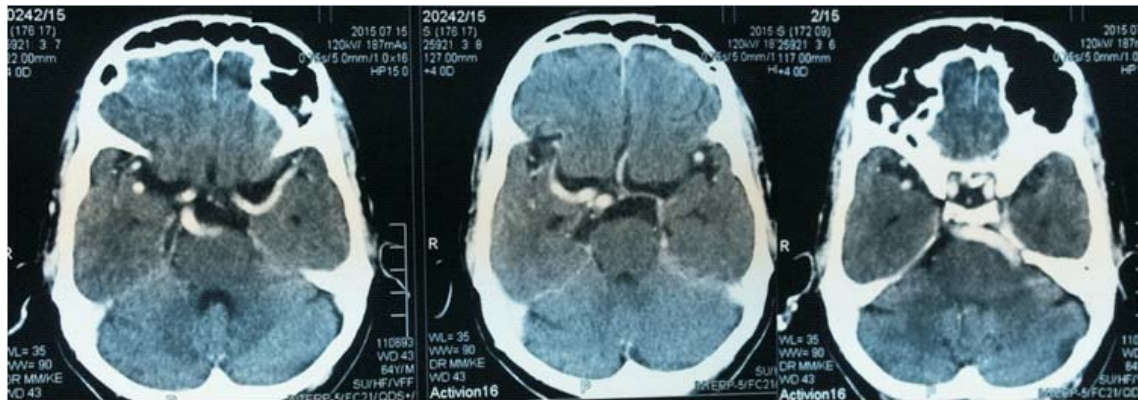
Contrast CT showing vertebrobasilar dolichoectasia
